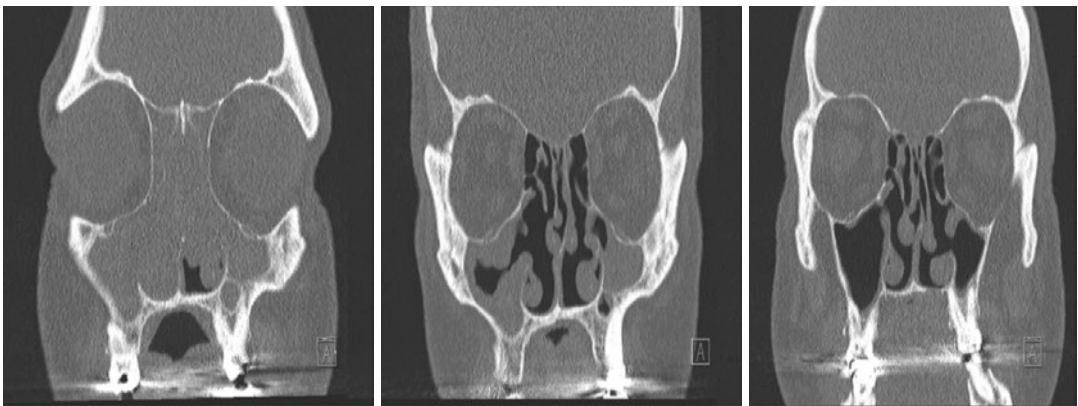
Sinus CT scans over 1 year (left to right) of a CRSwNP subject under the treatment with Dupilumab
